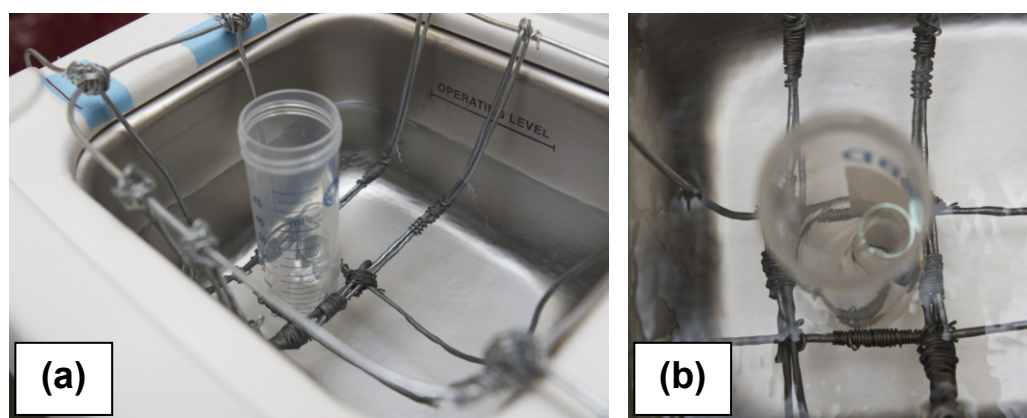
(a) Experimental setup for the disaggregation experiments. (b) The DLS vial containing the aggregate sample was held in a 50-mL centrifuge tube secured in the cage during ultrasonication.
